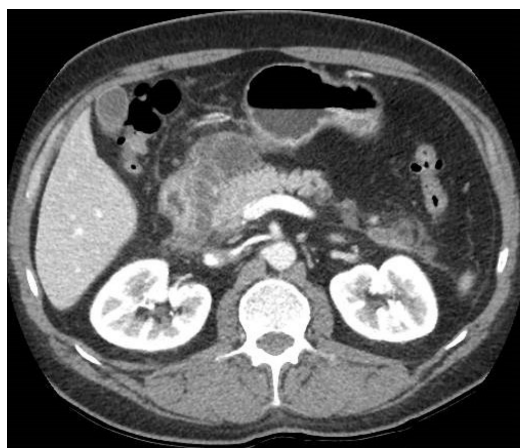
A 60-year-old man with abdominal pain and increased amylase and lipase levels. Abdominal contrast-enhanced portal-venous phase computed tomography image showed fluid collections at the level of the pancreatic head and isthmus region and thickening of the left anterior pararenal fascia and perivisceral fat.
